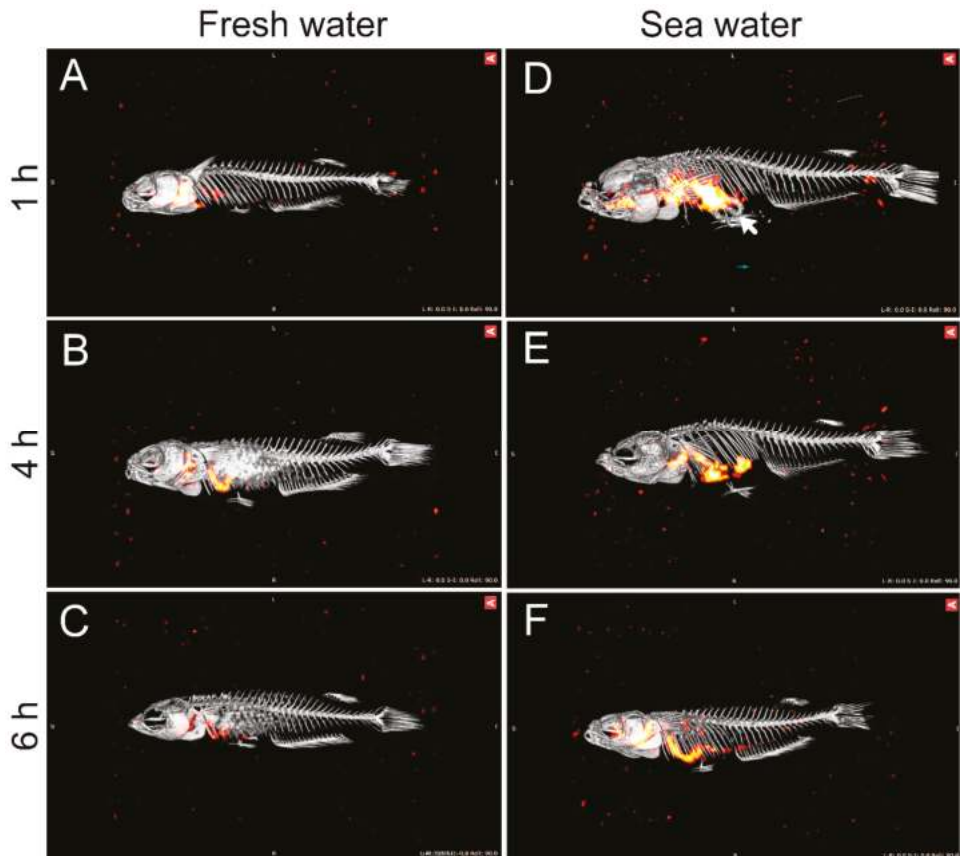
Visualization of the movement of imbibed water along the gastrointestinal tract of medaka acclimated to FW (A–C) or SW (D–F). Images are merged from single photon emission computed tomography (SPECT) (red intensity layer) and computed tomography (CT) (gray) scans of fish which had been incubated in ^{99}Tc -DTPA traced FW or SW for 1 h followed by transfer to non-radioactive FW or SW for 1 h (A, D), 4 h (B, E), or 6 h (C, F). The SPECT layer visualizes the localization (and intensity) of imbibed isotope-labeled water and the CT layer visualizes mineralized structures (skeleton and mineral precipitates in the SW intestines, white arrow in D). Note that ^{99}Tc has a short half-life (6 h), which influences the apparent intensities of the imbibed isotope. The fish was approximately 3 cm in length.
